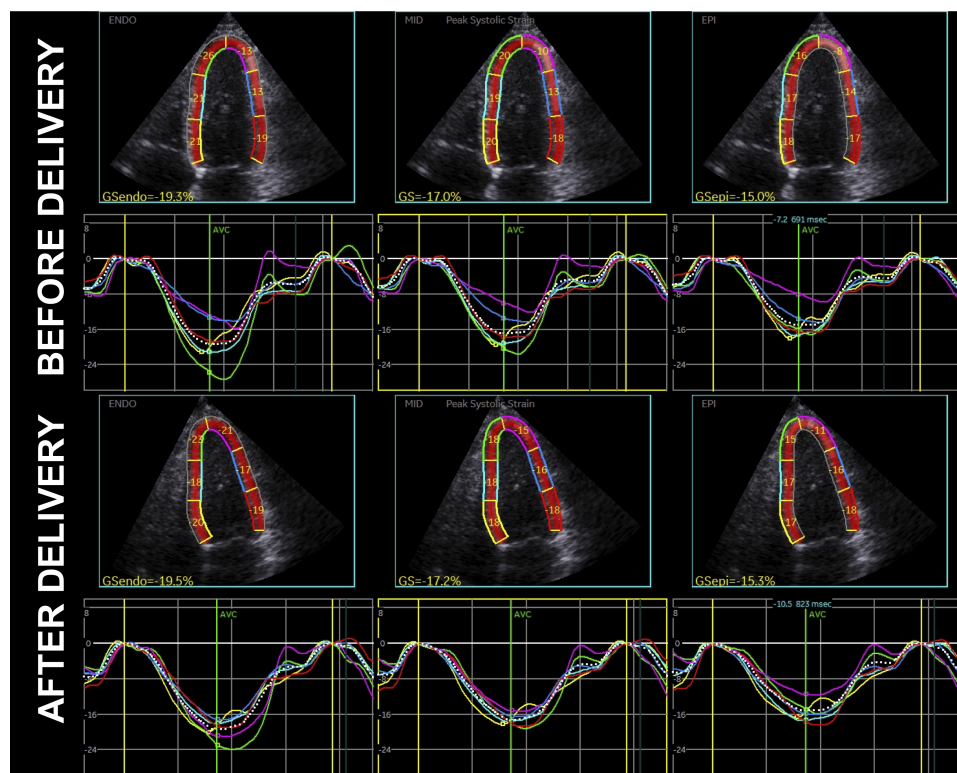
Layer-specific longitudinal strain analysis using two-dimensional speckle-tracking echocardiography for evaluating left-ventricular systolic function in a woman affected by pre-eclampsia, before delivery (upper rows) and in the immediate postpartum period (lower rows).
